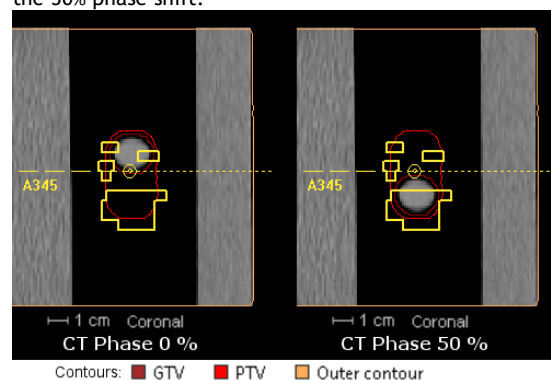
Example for the occurrence of interplay effects: IMRT plan segment on two CT Phases
